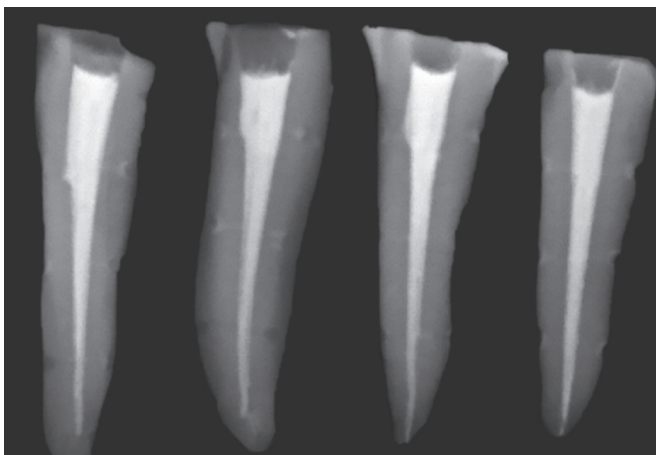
Digital radiograph of mandibular premolars obturated with MTA Fillapex sealer
